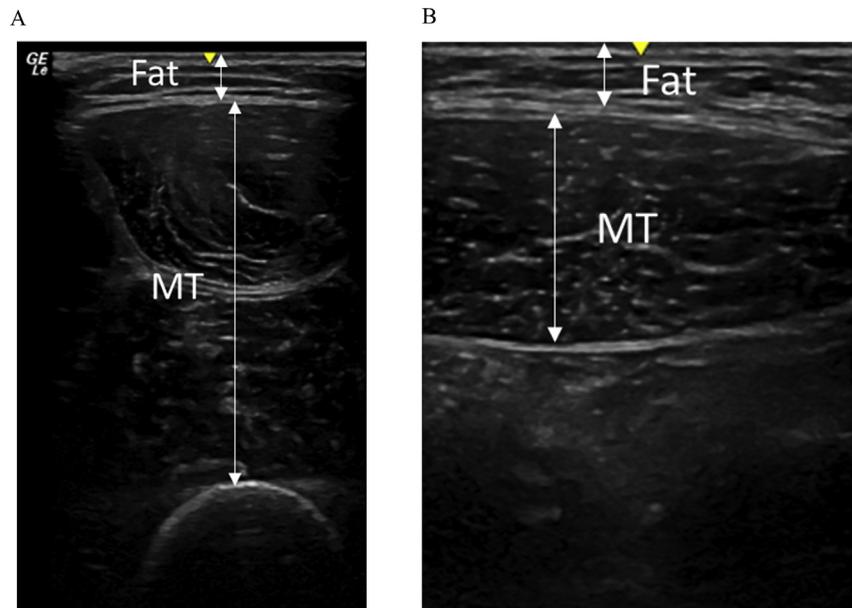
Ultrasound measured subcutaneous fat thickness (FAT) and muscle thickness (MT) of the anterior thigh (A) and anterior trunk (B).
